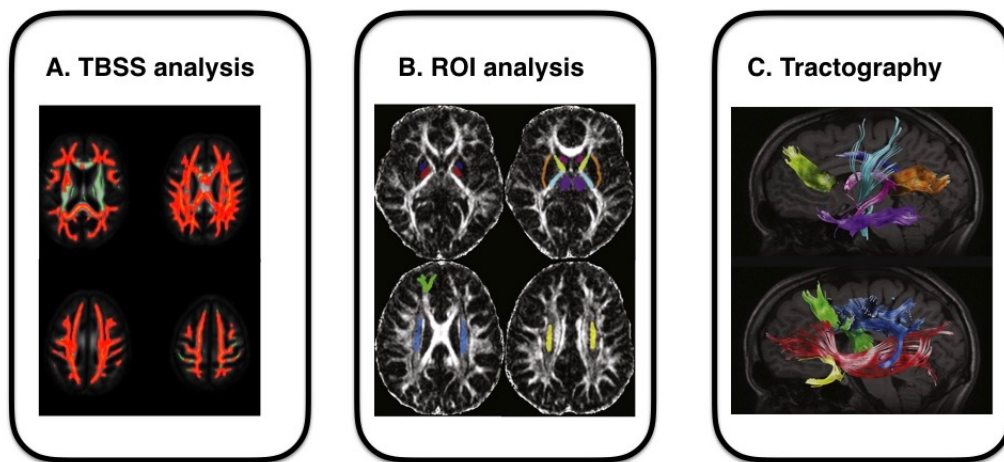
Popular image analysis methods in diffusion MRI. Figure B and C were adapted from Lebel et al., 2008 [112]
